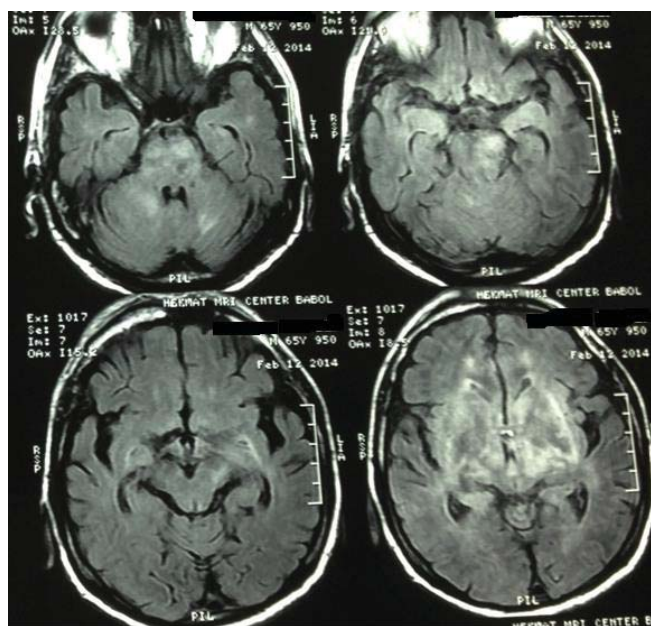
Magnetic resonance imaging of the brain revealed bilateral infiltrative lesions in brainstem, basal ganglia, medial temporal and cerebellum.
